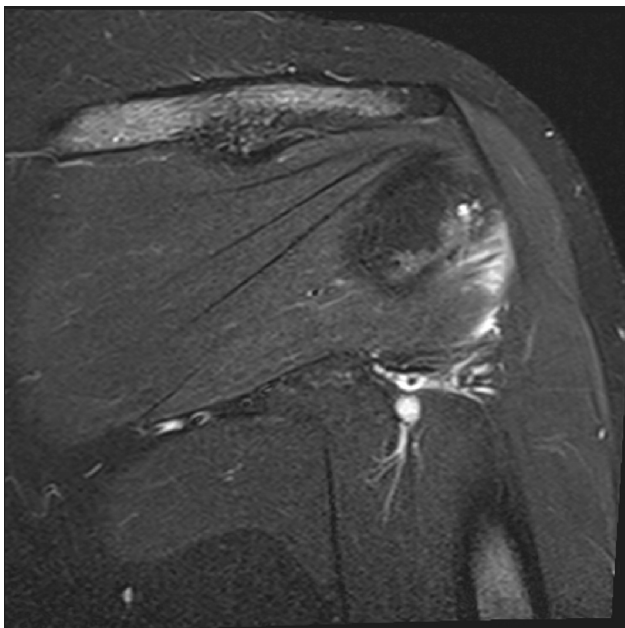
Case 2. STIR coronal MRI sequence demonstrating increased signal in the distal teres minor tendon consistent with edema and or tendinopathy.
